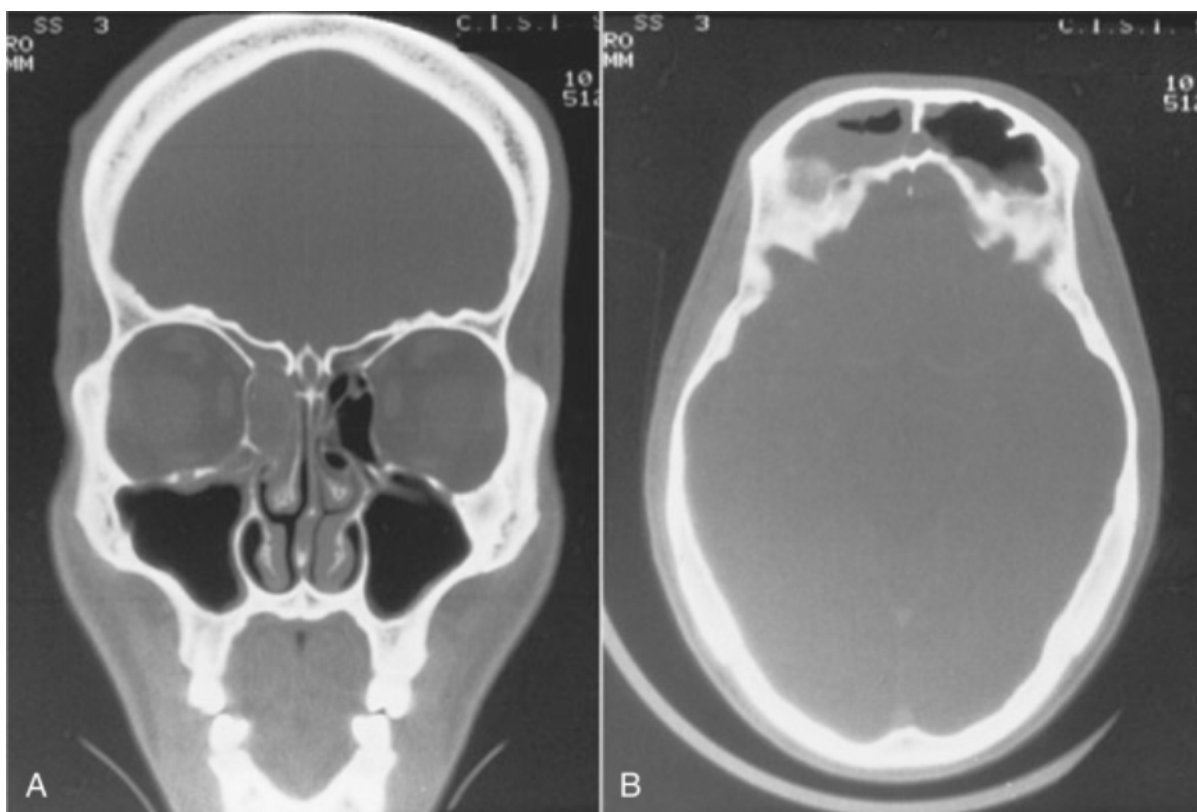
A, Coronal computed tomography (CT) scan demonstrating right-sided frontal opacification with involvement of the anterior ethmoid sinus. B, Axial CT scan displaying the air-fluid level in the right frontal sinus.
